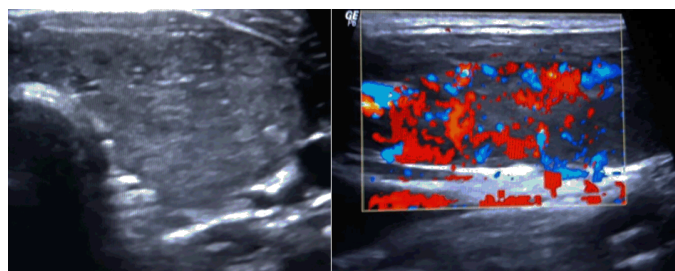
Cervical sonography: Hypoechoic heterogeneous thyroid gland with global hyperemia.
